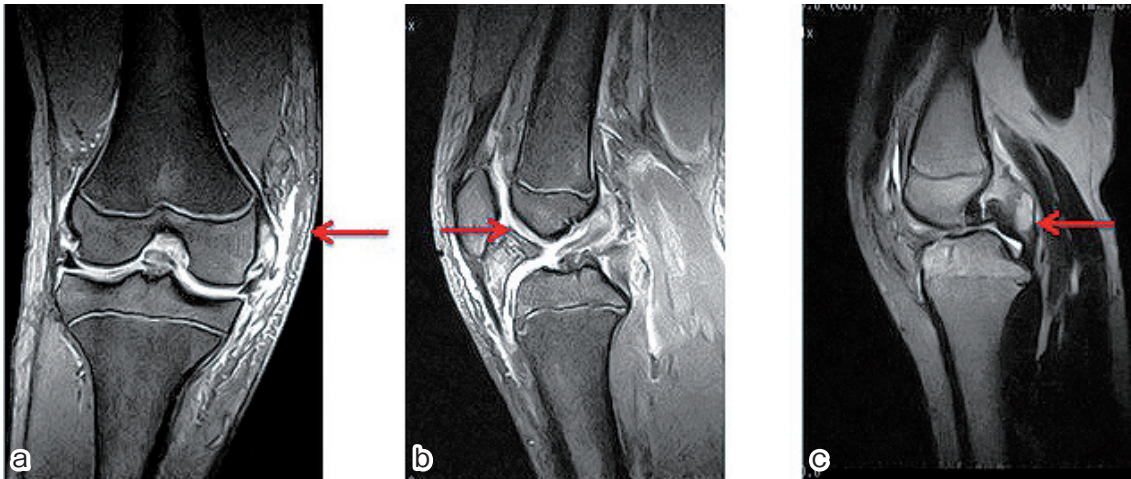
MRI indicated the disruption of the MCL at the tibial side (a), the ACL at the tibial side (b) and the PCL at the femoral side (c).
